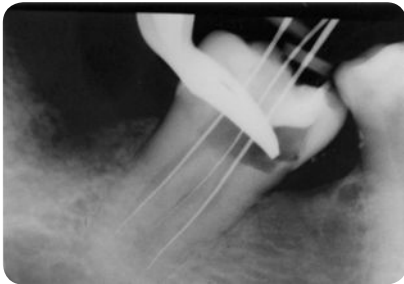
The middle instrument has been placed in a thin connecting isthmus of this C-shaped molar. The file appears to have perforated the furcation since the isthmus is too thin to be radiographically evident.
